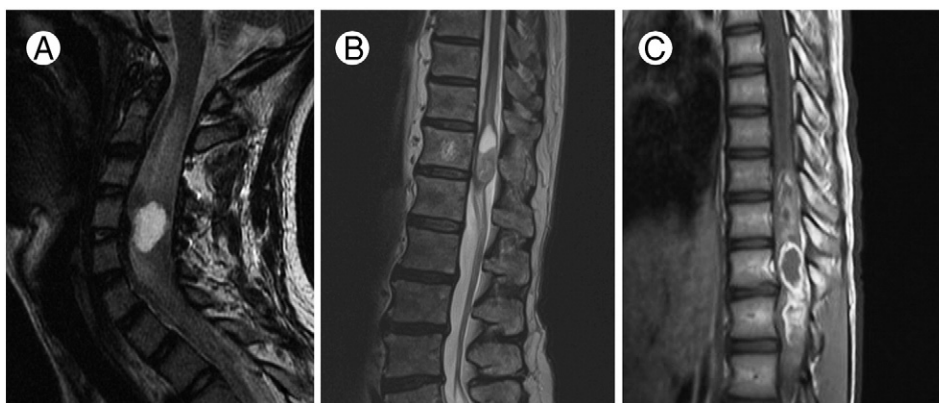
Neuroradiological features of spinal gangliogliomas described in this series. A, A T1 hyperintense tumor at C4 level appeared well demarcated from surrounding CNS tissue (case 7). B, A contrast-enhancing tumor located at T12-L1 (case 11) shows partially cystic features. C, The magnetic resonance imaging scans display a partially cystic, partly solid, and contrast-enhancing intramedullary ganglioglioma at T12 level (case 6). The lesion is T1 hyperintense and contrast-enhancing with numerous cysts located centrally.
